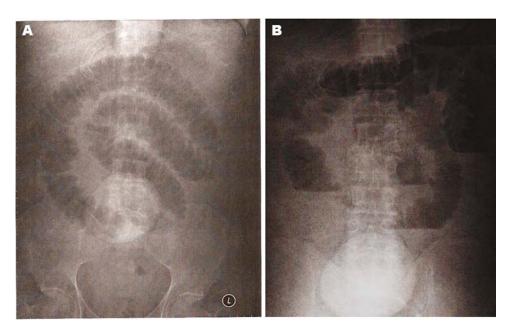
(A) Abdominal x-ray of patient with incarcerated umbilical hernia. (B) Abdominal x-rays revealing proximal small bowel dilatation and air fluid levels.
